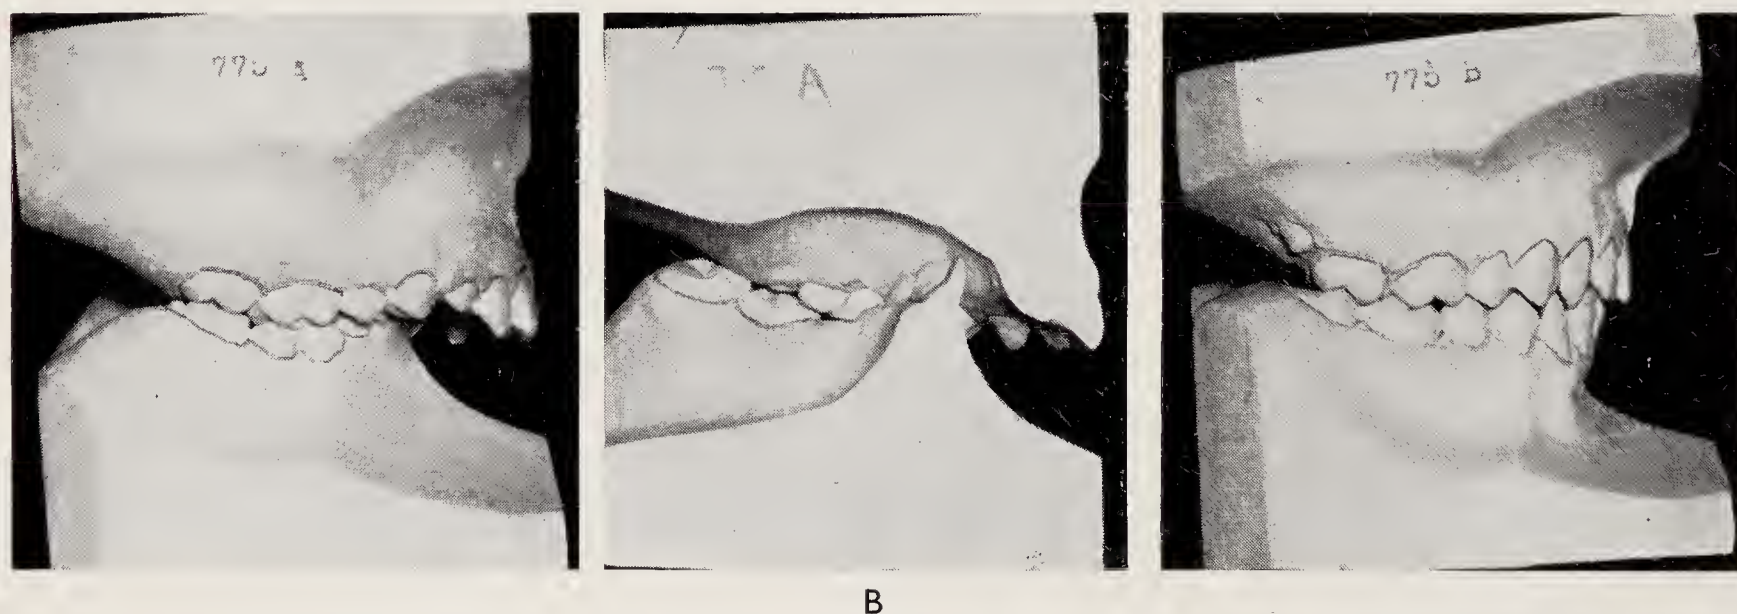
Case 775. Age $11\frac{1}{2}$. Angle Class II, division 1. Treatment with functional appliances from January, 1949, to December, 1953. Loss of right mandibular first molar. A, Superimposed tracings of lateral radiographs. B, Models at beginning of treatment, March, 1949, and at completion of treatment, December, 1953.
